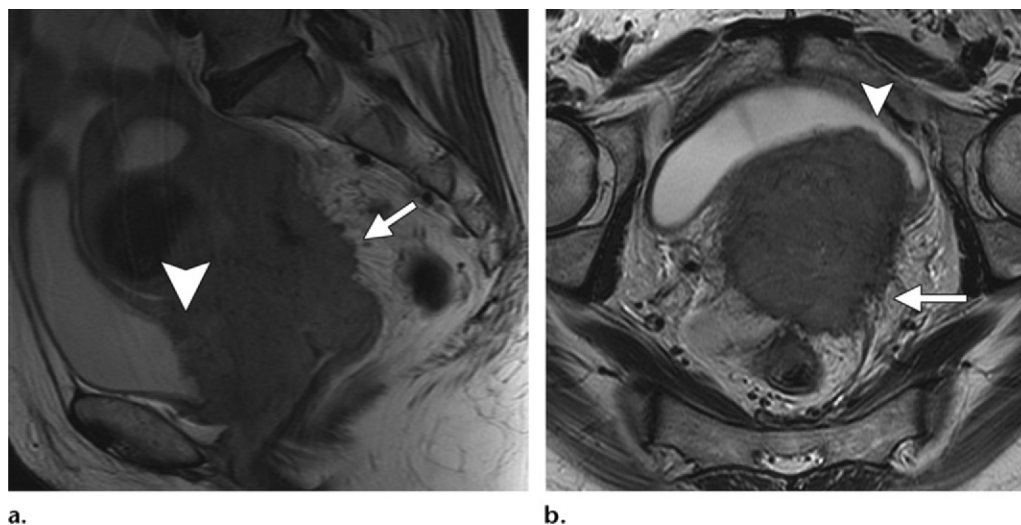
Locally advanced cervical cancer with bladder involvement at high-resolution MR imaging. (a) Sagittal high-resolution T2-weighted FRFSE MR image shows a large mass replacing the entire cervix and invading the body of the uterus. Note extension of tumor into the bladder mucosa (arrowhead) and perirectal fat (arrow). (b) Oblique high-resolution T2-weighted FRFSE MR image shows irregular protrusions of tumor circumferentially infiltrating the parametria, a finding consistent with bilateral parametrial extension that is more prominent on the left (arrow). Note invasion of the posterior wall of the urinary bladder with mucosal involvement on the left (arrowhead).
